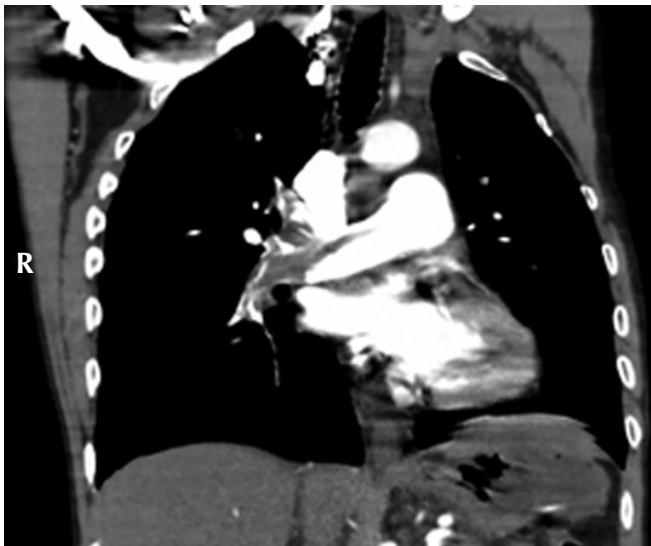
Coronal view of computed tomographic pulmonary angiogram showing a large saddle embolism at the bifurcation of the main pulmonary artery.
